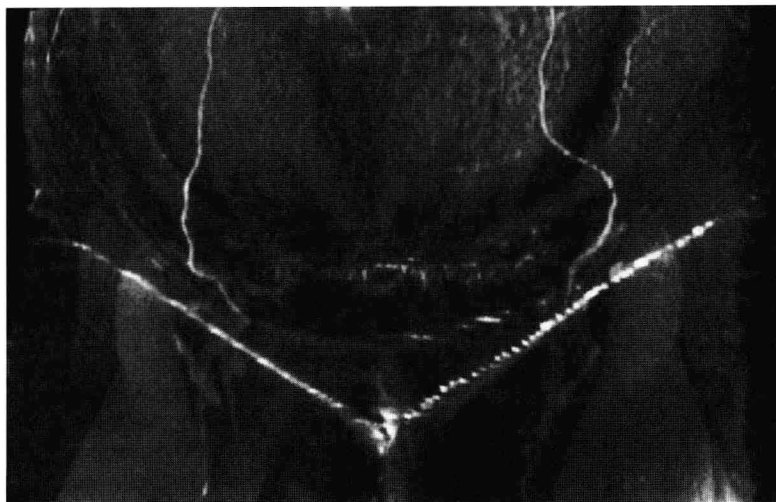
Spiral CT scan image of the frontal view of the lower abdomen. Note the course of the epigastric arteries from the inguinal region to the umbilicus.
